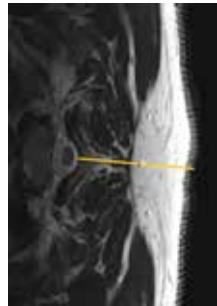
A cervical spine MRI in axial view was obtained for pre-procedural planning. The yellow line indicates the distance measured from the skin to the posterior epidural space
